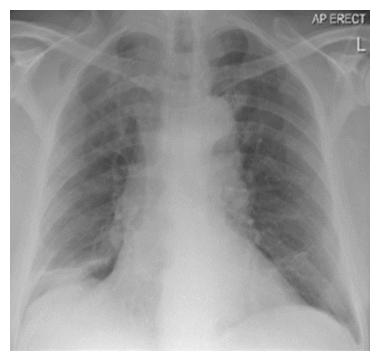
A chest radiograph typical of the indeterminate pattern(44).
